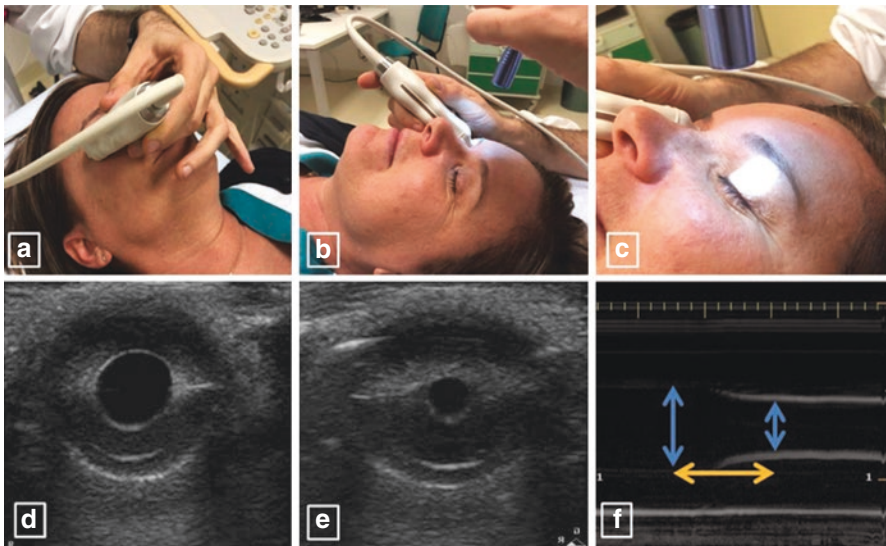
Ultrasound assessment of pupillary light reflex (PLR). (a) Initial probe positing; (b) elicitation of direct PLR; (c) elicitation of consensual PLR; (d) B-mode visualization of pupil at rest; (e) B-mode visualization of pupil in miosis after stimulus; (f) M-mode measurement of pupillary diameter (in blue) and pupillary constriction time (in yellow)
